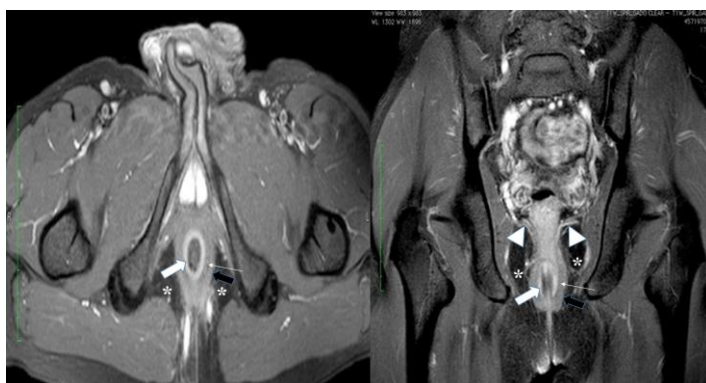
MRI post contrast axial and oblique coronal sections T1 weighted images showing the relevant perianal anatomy- internal sphincter (thick white arrow), external sphincter (thick black arrow), intersphincteric space (thin arrow), ischioanal fossa (asterix) and levator ani muscles (arrow heads).
